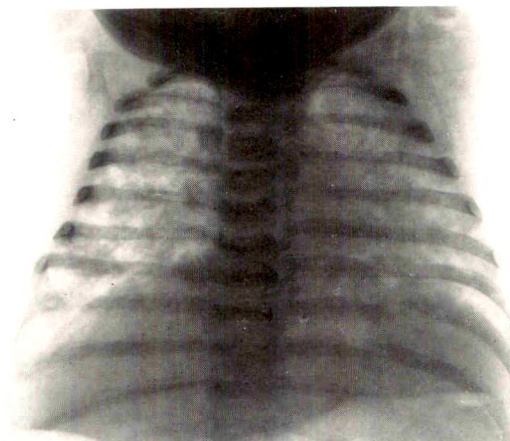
Necropsy film. Case of focal hemorrhagic pneumonia secondary to extensive furunculosis (*Staphylococcus aureus*). Note marked similarity of roentgen densities to Case II (Fig. 3).
